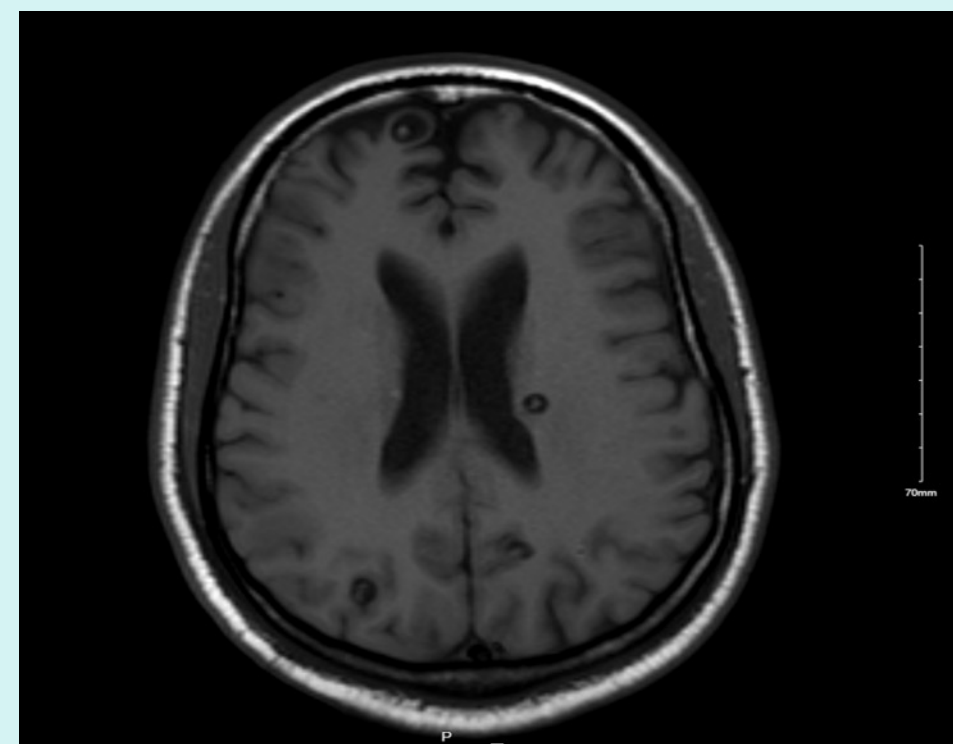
MRI brain showing multifocal cystic lesions without hydrocephalus
